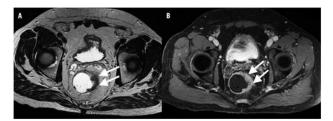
(A) Axial sequence MRI with T2 information and (B) axial sequence MRI with T1 information after contrast medium administration. At 7 cm from the anal flange a mass is identified in the left lateral wall of the rectum (white arrows) between 1 and 6 hours, 36 mm long and 9 mm thick, transmural, with a 7 mm component that infiltrates the mesorectal fat between 1 and 3 hours, 21 mm from the mesorectal fascia. There is heterogeneous enhancement after administration of intravenous contrast medium.
